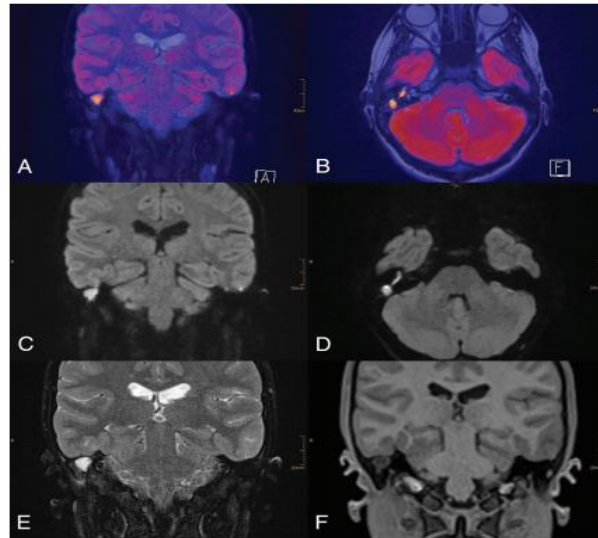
Description of cholesteatoma in MRI
